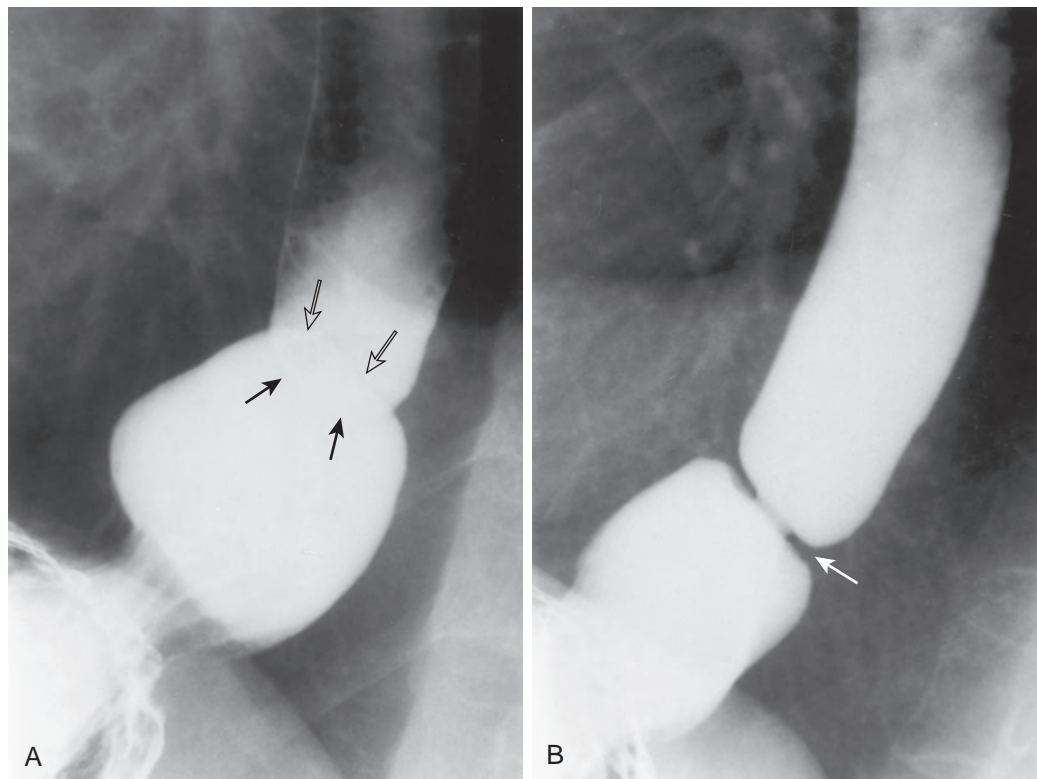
Overlap phenomenon obscuring Schatzki ring. A. Prone single-contrast view of the distal esophagus shows a hiatal hernia without evidence of a lower esophageal ring. However, there is a double density with two superimposed convex collections of barium caused by overlap of the distal end of the esophagus (solid arrows) and the proximal end of the hernia (open arrows). B. Repeat view with less distention of the hernia shows a tight Schatzki ring (arrow) when the distal esophagus and adjacent hiatal hernia no longer overlap. (From Hsu WC, MS Levine, Rubesin SE, Overlap phenomenon: A potential pitfall in the radiographic detection of lower esophageal rings, *AJR*, 180, 745-747, 2003.)
